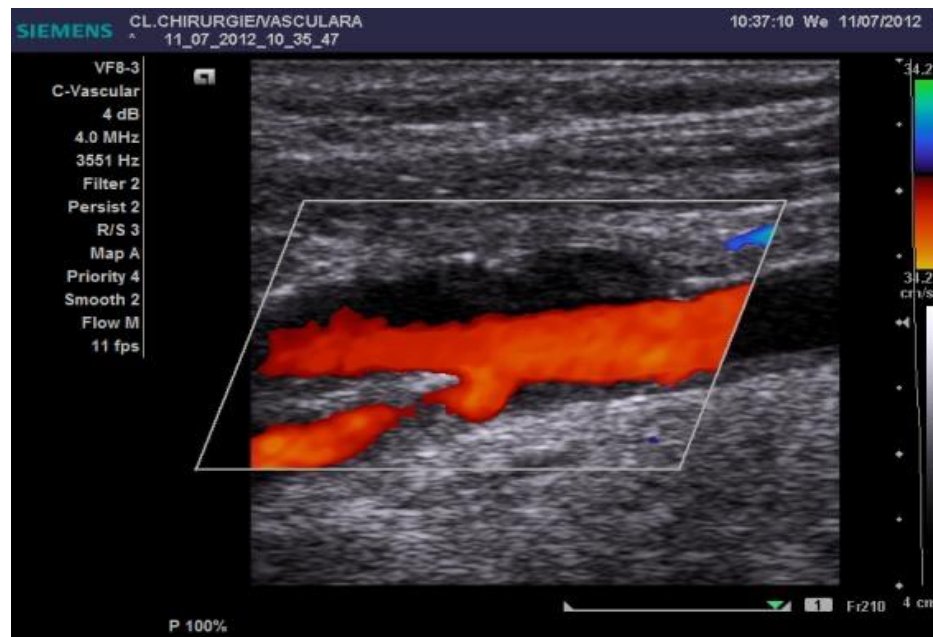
Follow-up: carotid angioplasty Doppler US
